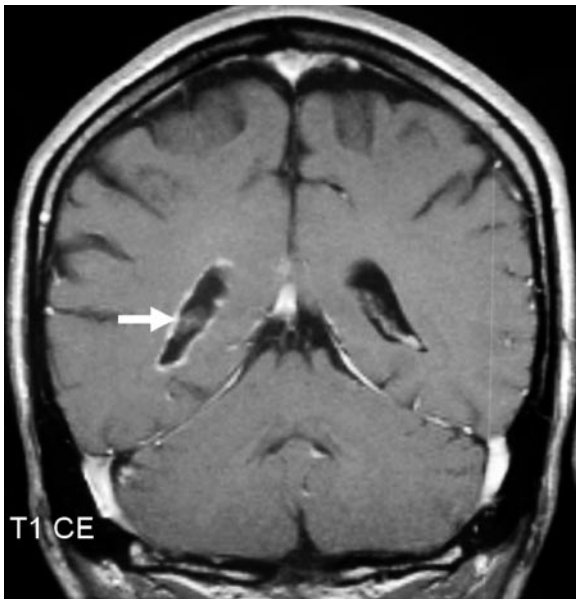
Tuberculous endyemylitis (ventriculitis) in a 53-year-old patient with tuberculous meningitis. Coronal T1-weighted image after contrast administration. Ependymal enhancement (arrow). (Courtesy of J. Spreer)
